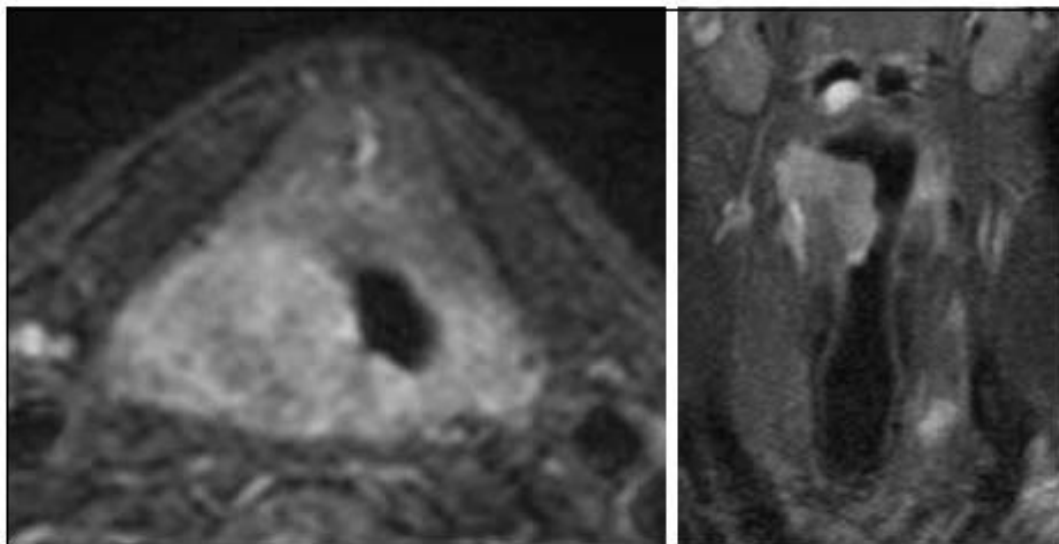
a-b) MRI in axial and coronal view of right glottic T3 with fixed vocal cord and arytenoid, extending posteriorly to the pyriform sinus submucosa and reaching the posterior commissure and posterior crico-arytenoid muscles.
